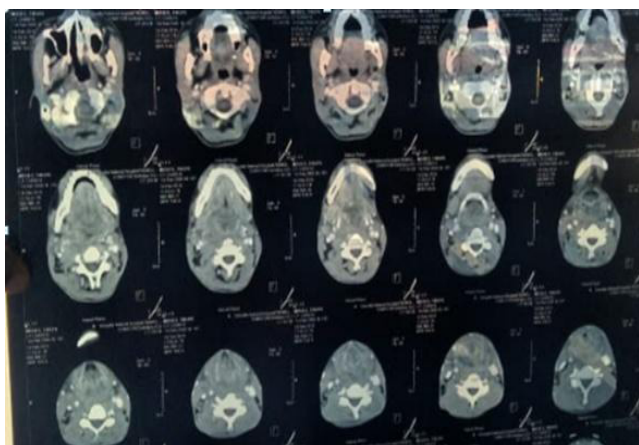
CT scan images show a bulky soft tissue mass in the hypopharynx extending to the oropharynx and the larynx
